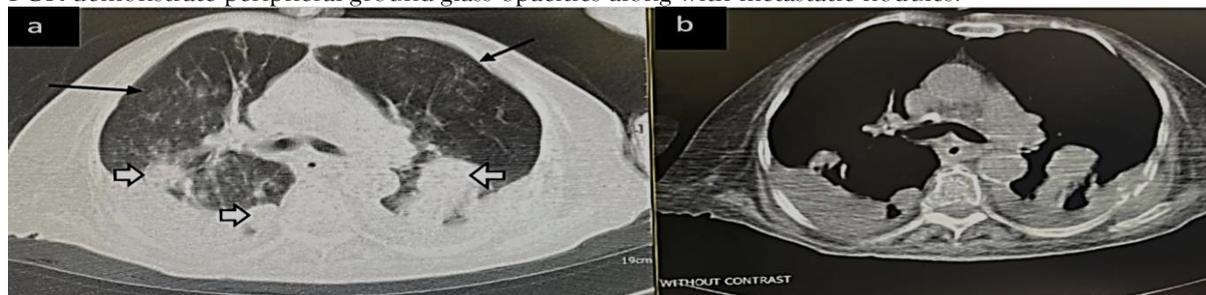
Axial unenhanced CT images of the lungs with hepatocellular carcinoma and positive RT-PCR demonstrate peripheral ground-glass opacities along with metastatic nodules.
